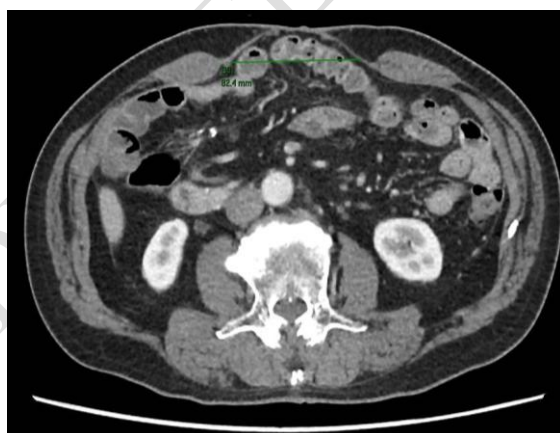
CT showing 8 cm incisional hernia defect
